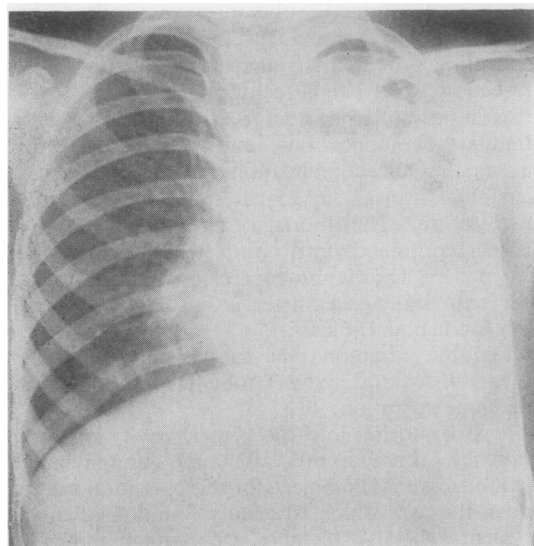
Chest radiograph of patient 2. There is contraction of the left lung with widespread cavity formation, together with some consolidation in the right lower zone.
